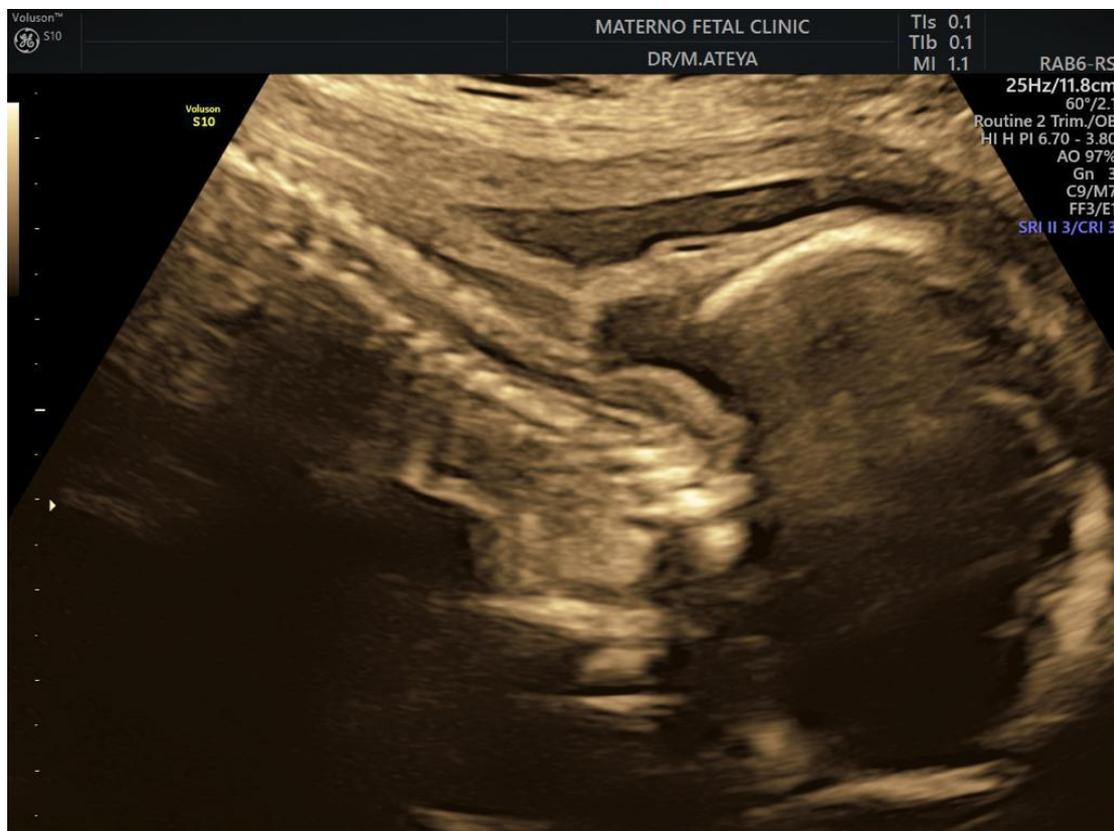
Two-dimensional ultrasound showing a case of cervical spina bifida.
